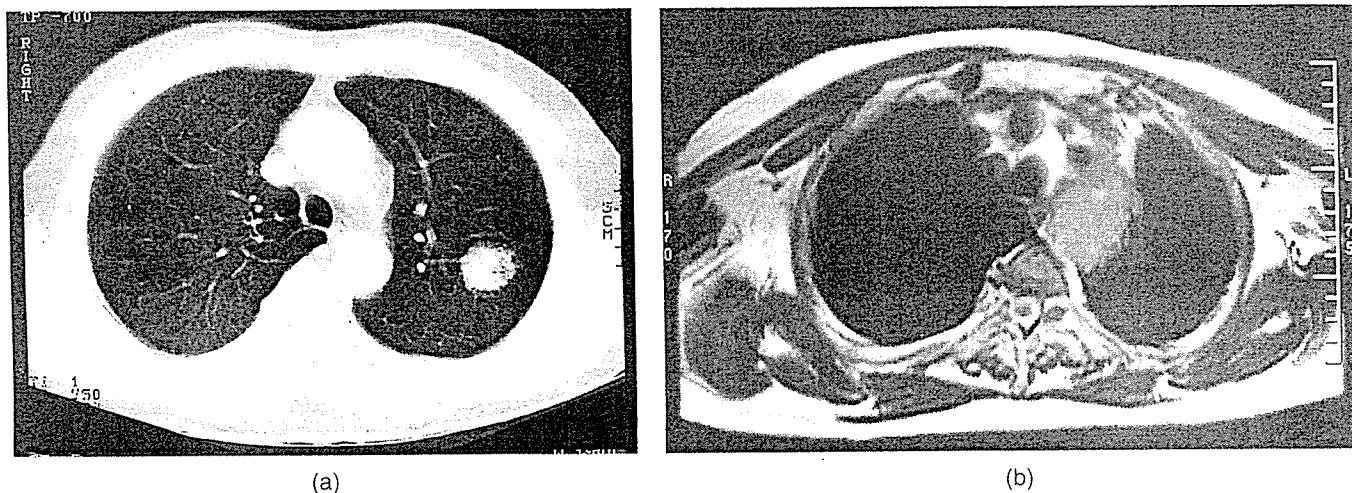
Findings on Chest CT (a) at diagnosis in July 1994 in Case 1. Findings on MRI (b) at relapse in 2004. There is mediastinal lymph node enlargement; size, 40 × 50 mm.
